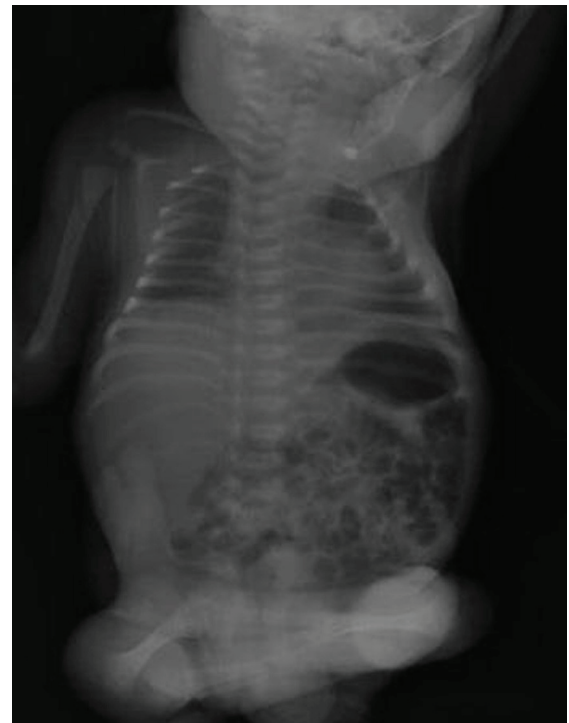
The antero-posterior radiography showed the 'sitting Buddha-like position', that was the result of the flexion-abduction of the hip joints, flexion of the knees, and equinovarus deformity.
